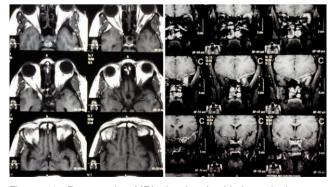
Preoperative MRI showing It sided meningioma enplaque
